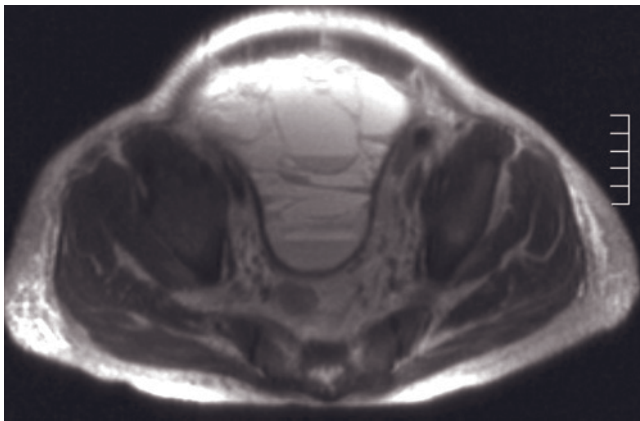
Peritoneal metastases from ovarian cancer. Transverse T2-weighted SS-ETSE (a), transverse T1-weighted SGE (b), coronal T2-weighted SS-ETSE (c), and delayed postgadolinium T1-weighted fat-suppressed SGE (d) images in a patient with ovarian cancer demonstrate multiple liver and peritoneal metastases. The largest masses exhibit multiple thin septations that are well shown on single-shot T2-weighted images and reveal enhancement after gadolinium.
